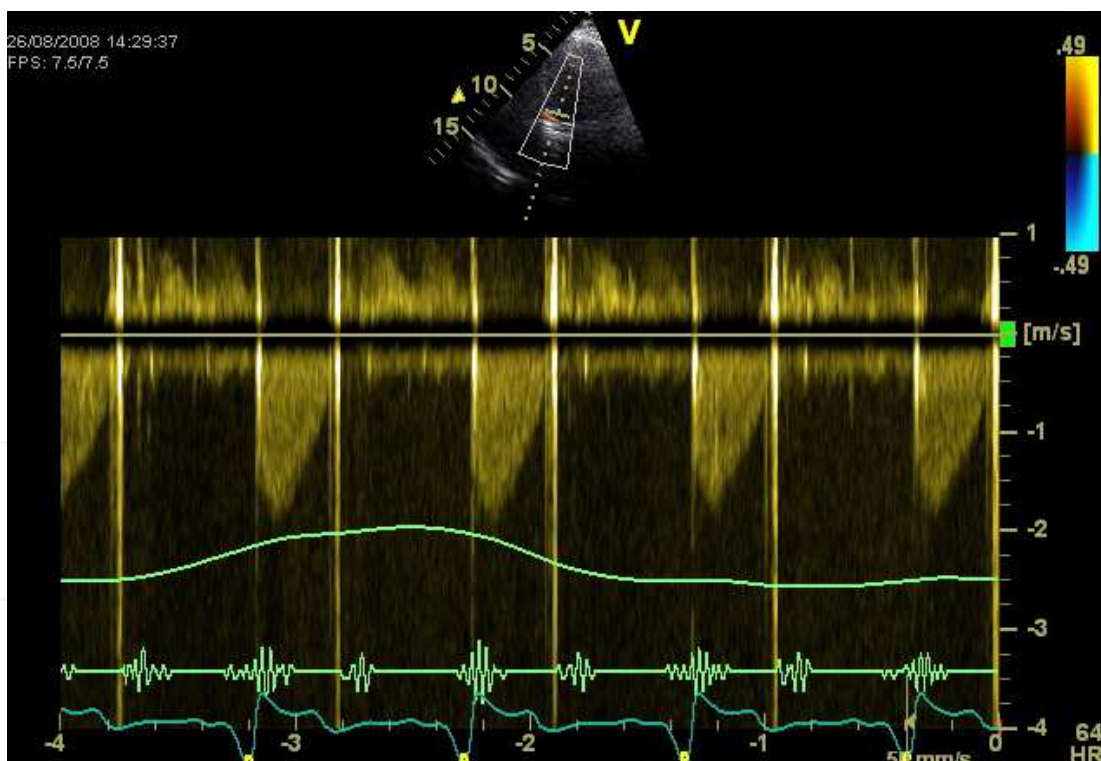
Continues Doppler velocity of the aortic valve, in the same patient, two weeks after aortic valve replacement.
